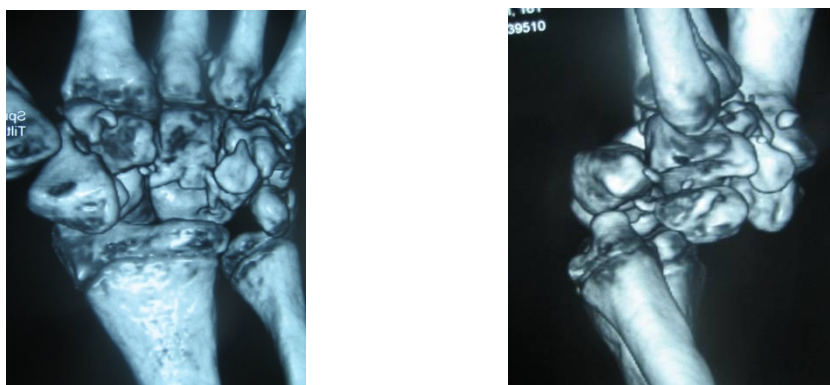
Preoperative CT scans of the wrist.
